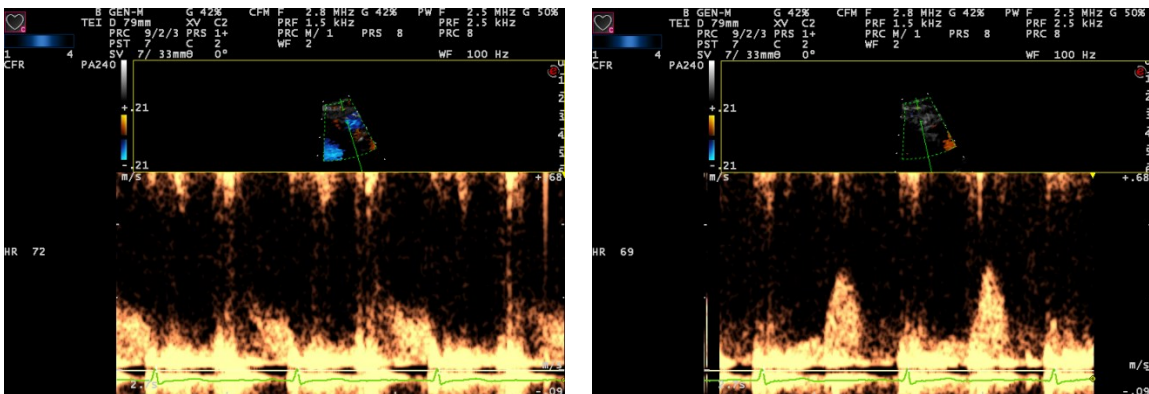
Example of different parts of coronary cycle imaged through pulse-wave Doppler positioning.
